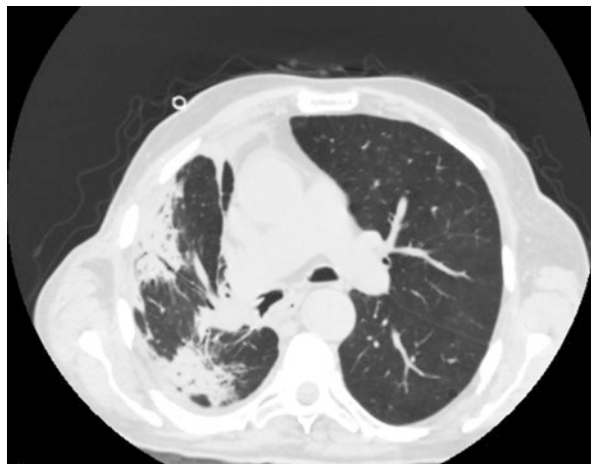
CT image of right pneumonia after the left pneumonectomy
